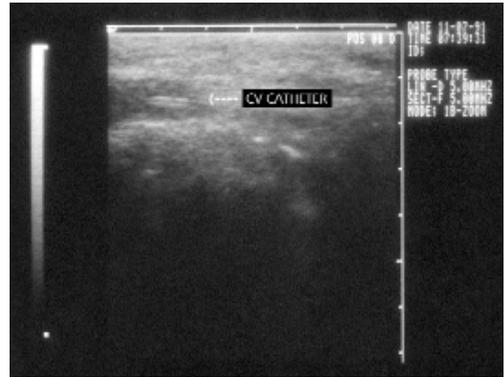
Ultrasonographic transversal presentation of v. subclavia (linear transducer; 5 MHz). Double echo in vein presents central venous catheter.
